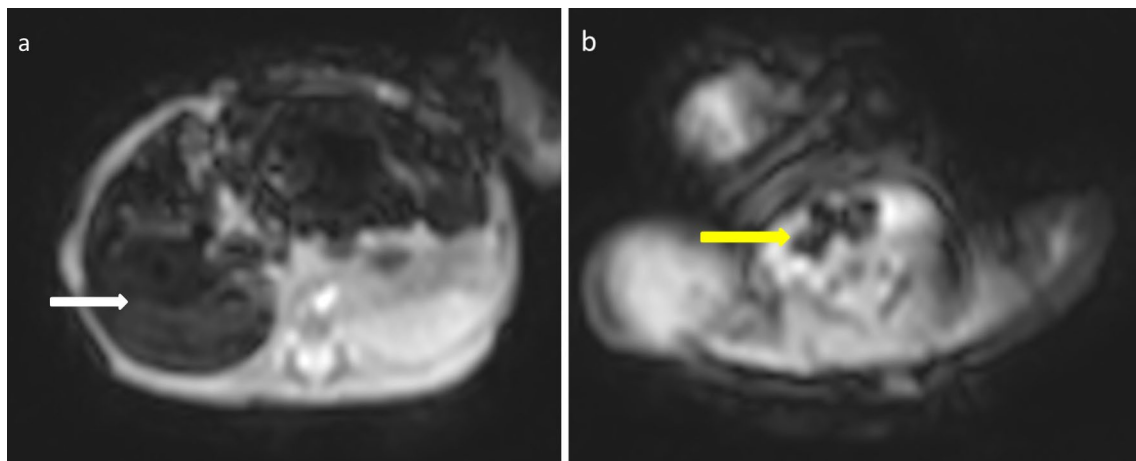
(a,b) T2* weighted axial postnatal MRI images show hypointense signal of liver (white arrow) and thyroid (yellow arrow)
